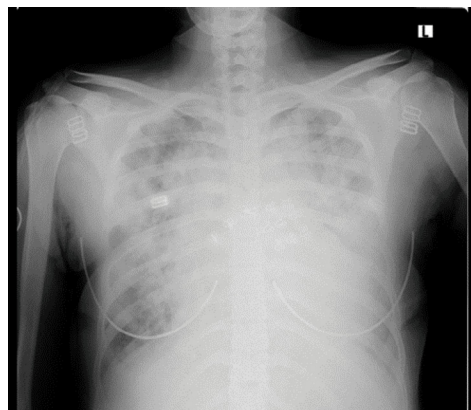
Chest x-ray before treatment.
